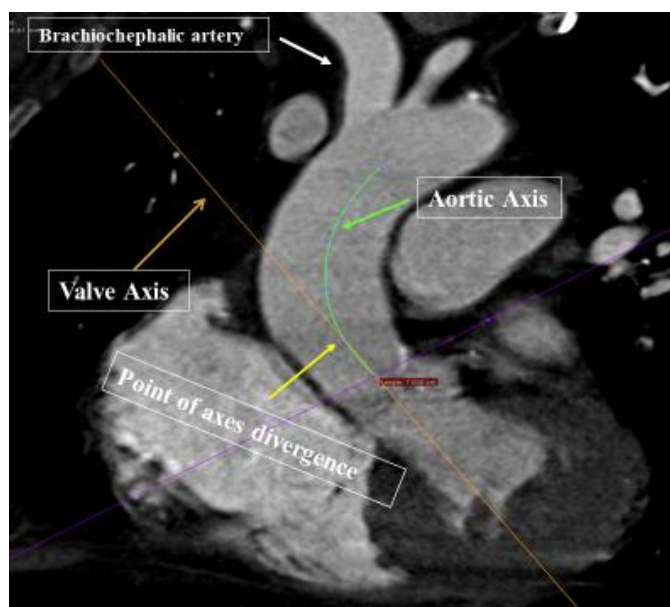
CT scan. Yellow-brown line represents the axis perpendicular to the annulus plane. Green line represents the axis of the aorta. Yellow is the point at which the two axes diverge.
